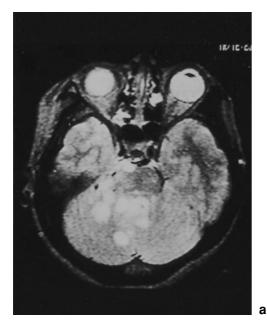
Magnetic resonance imaging. (a) T2-weighted axial image showed multiple high signal intensity masses in the brain stem, cerebellar hemisphere and cerebellopontine angle. (b) T1-weighted sagittal and coronal image showed iso- or low signal intensity masses in the brain stem and cervical spinal cord
